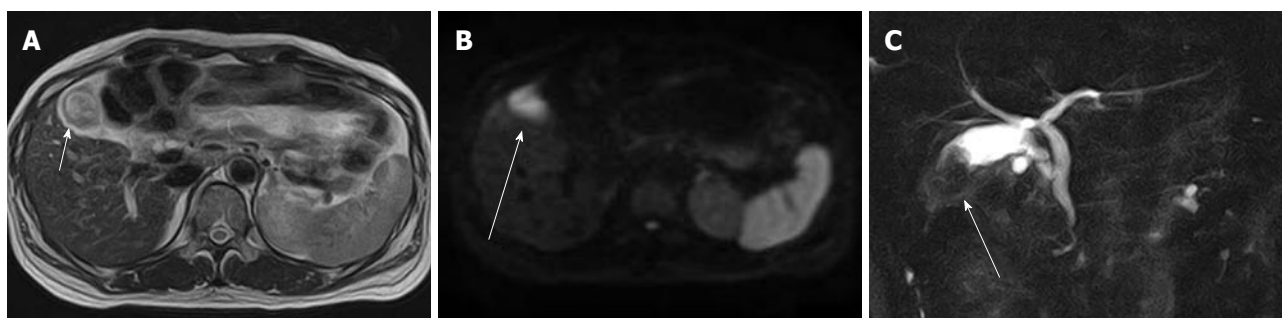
Gallbladder carcinoma in a 56-year-old woman. A: Axial T2-weighted image shows focal wall thickening (arrow); B: Diffusion-weighted imaging shows high signal intensity in the lesion (arrow); C: Magnetic resonance cholangiopancreatography shows a filling defect in the gallbladder (arrow). Abnormal arrangement of the pancreato-biliary ductal system is identified.
